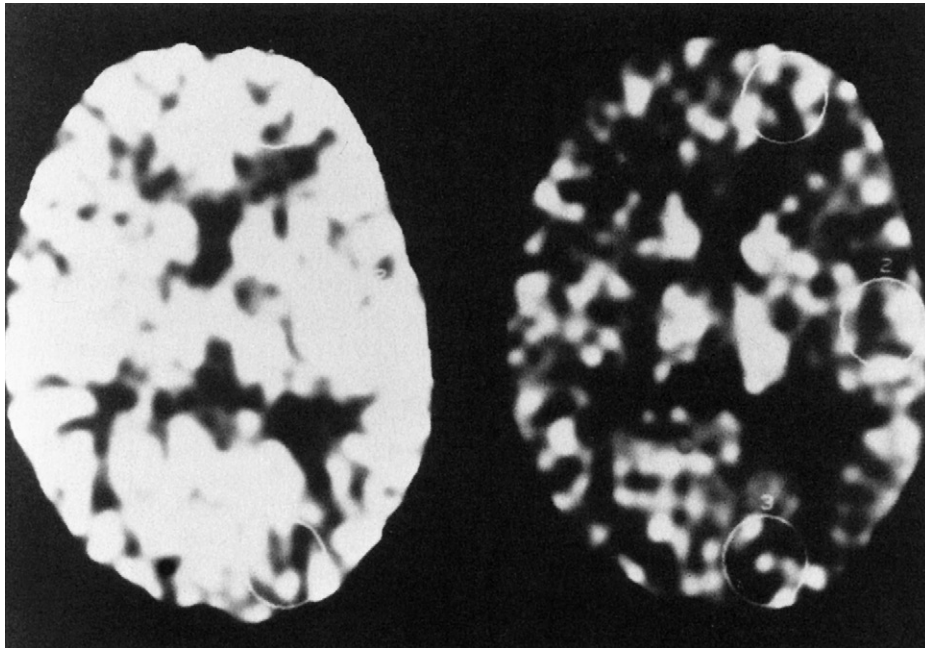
Stable-xenon computed tomography (CT) cerebral blood flow study in a comatose 6-year-old 3 days after cold-water submersion accident with asphyxial cardiorespiratory arrest. Delayed CBF hyperemia is represented as high-density white areas through the CT brain section shown on the left (PaCO₂ ~40 mm Hg). Flows (calculated from this scan) are in excess of 100 mL/100 g/min throughout the brain. Normal values are ~60 to 70 mL/100 g/min. Despite diffuse hyperemia, CBF reactivity to changes in PaCO₂ remain intact. CBF values ranged from 50 to 60 mL/100 g/min (right) in areas sampled when PaCO₂ was reduced to 29 mm Hg with hyperventilation. Six months after the arrest, the child was moderately disabled but not in a vegetative state.
